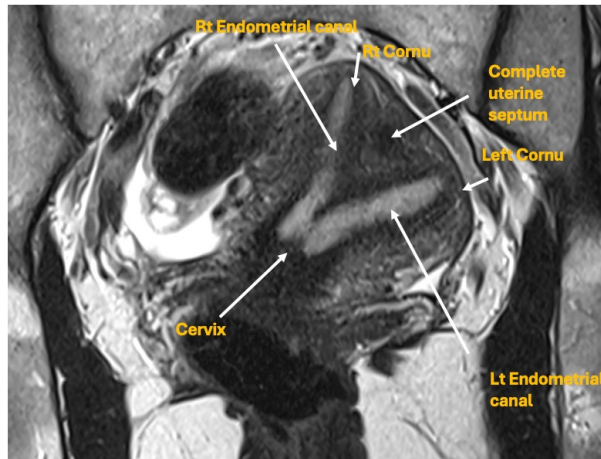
Pelvic magnetic resonance imaging (MRI), T2 weighted coronal view.
